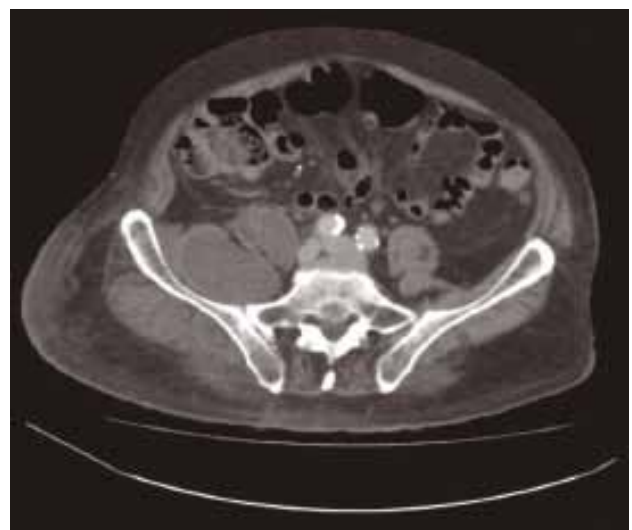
A CT scan demonstrating a right-sided iliopsoas compartment collection.
